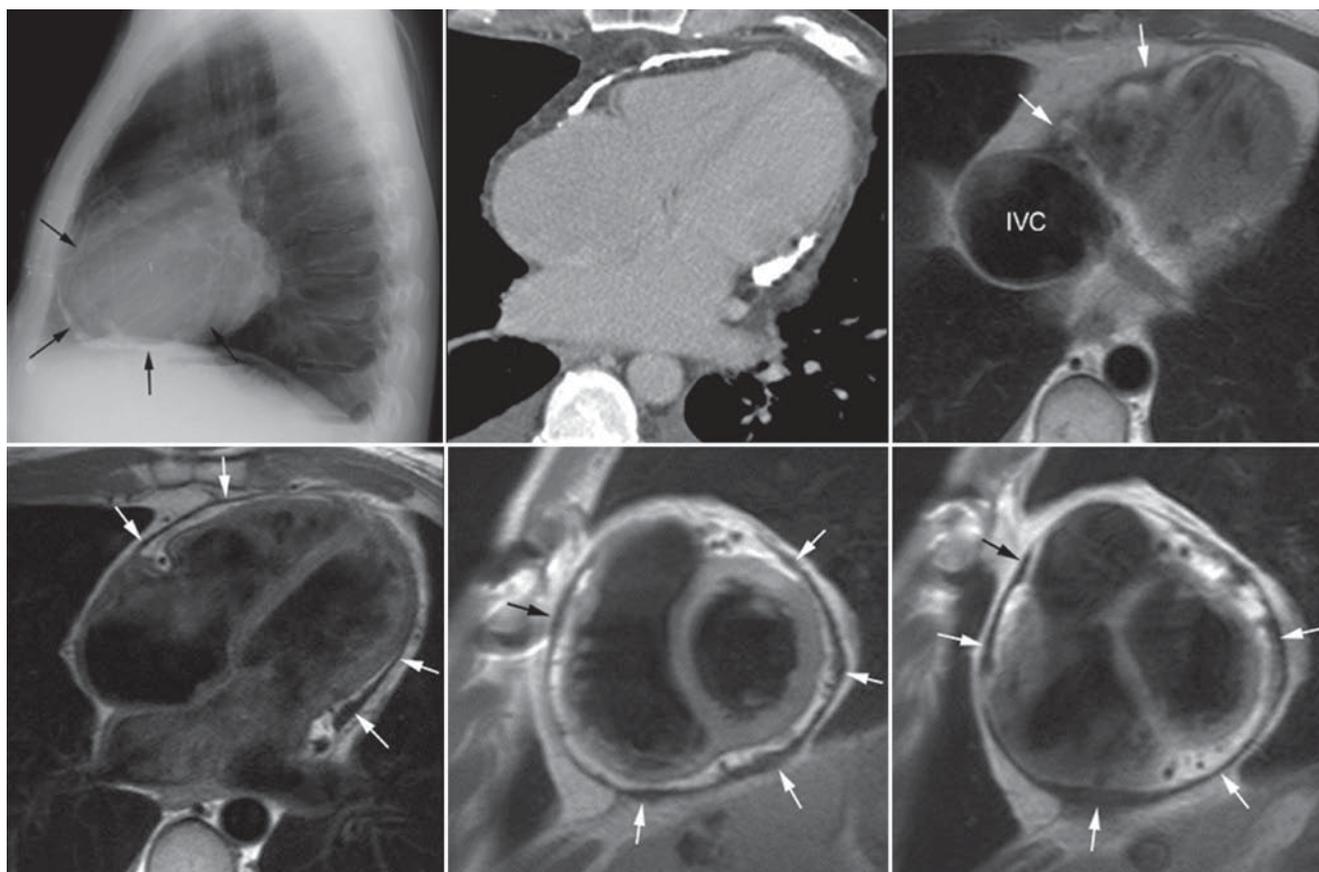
Findings on chest X-ray, CT, and CMR of a patient with constrictive pericarditis and calcified pericardium. The low signal intensity, thickened pericardium on CMR corresponds to the calcified
